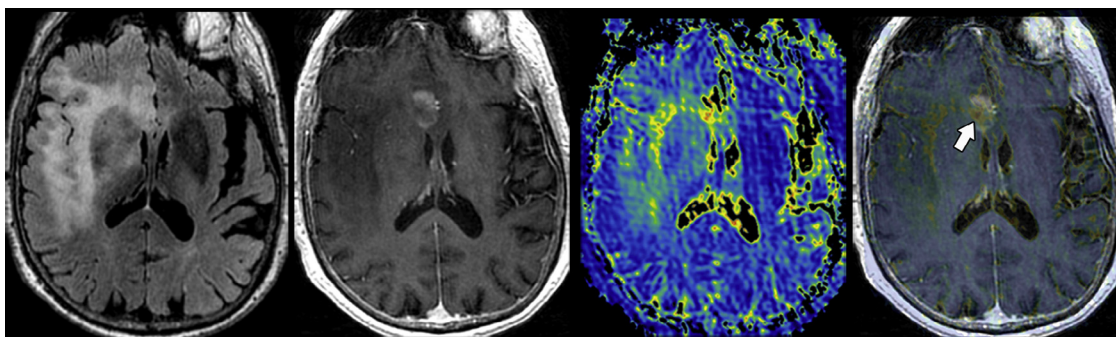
Preoperative MRI of a right frontal temporal mass lesion. An 84-year-old man presented to our institution with a T2/FLAIR hyperintense mass (left image) within the right frontal operculum with extension into the right subinsular white matter, anterior cingulate, right anterior temporal, and mesotemporal lobes. Focal contrast enhancement (center left image) was observed within the right cingulate gyrus. Despite the patient's past medical history of lung adenocarcinoma, the morphologic appearance of the mass was believed to be likely due to a high-grade primary glial neoplasm. T1 ρ MRI (center right image) demonstrates heterogeneous spin-lock contrast values within the enhancing and nonenhancing tumor components. Fused T1 ρ and T1-weighted postcontrast image (right image) demonstrates a focal region of markedly elevated T1 ρ within a nonenhancing tumor component (arrow). MRI, magnetic resonance imaging.
